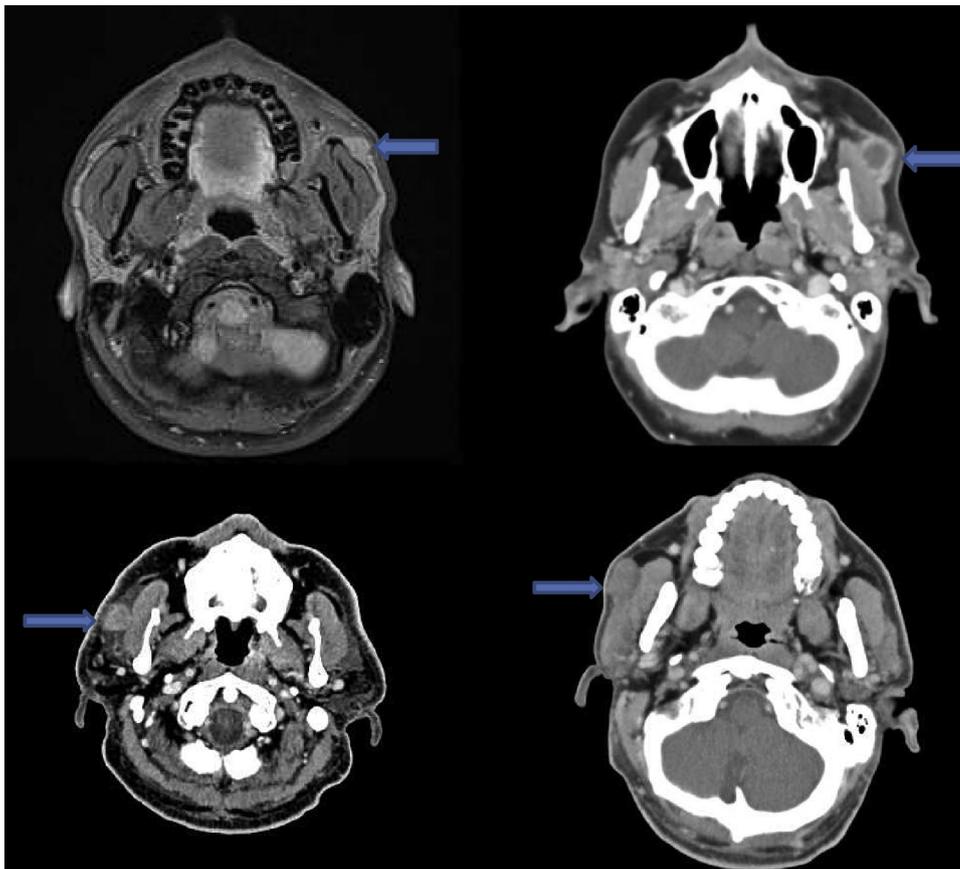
Magnetic resonance imaging and multi-slice computed tomography scans of patients with accessory parotid gland tumours. Arrows point to the tumour.
